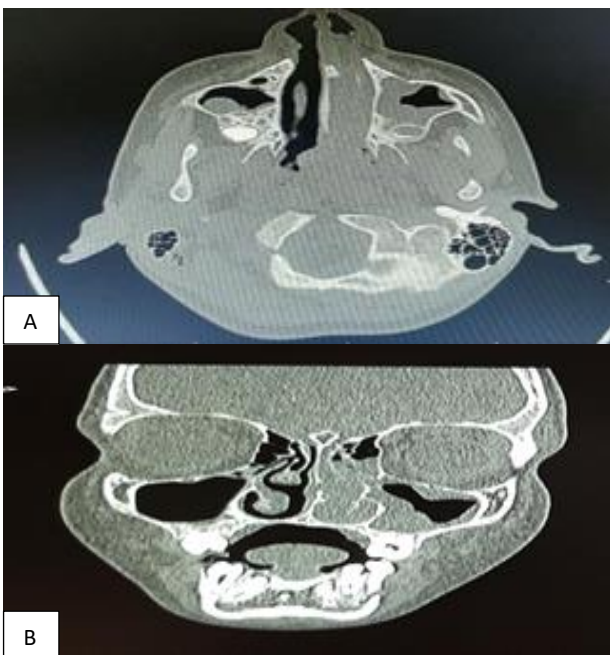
(A and B): CT-PNS of polyp arising from left inferior turbinate.
